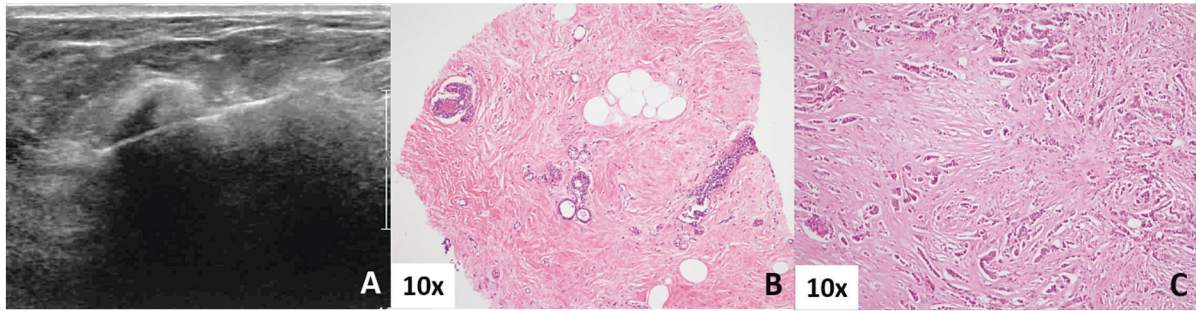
False negative case from sampling error. A, Ultrasonography during CNB biopsy. B, CNB; Usual ductal hyperplasia with sclerotic stroma. C, Open biopsy; Invasive ductal carcinoma with sclerotic stroma and desmoplastic reaction
